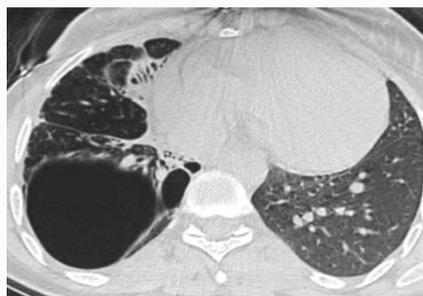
Thoracic computed tomography in parenchymal window showing a emphysema bubble in a patient treated previously for a tuberculosis.
